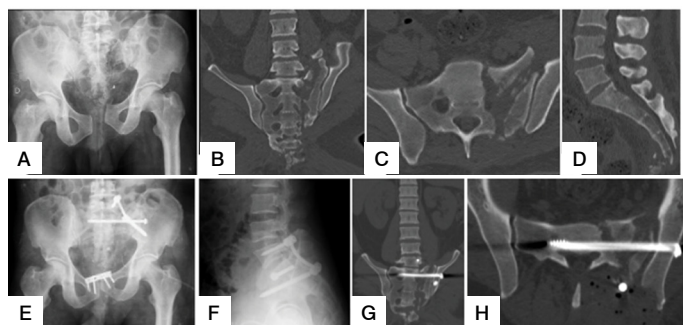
Male patient, 30 years old, a victim of a 9-meter fall with 30 days of evolution. On neurological examination, Gibbons 1. Imaging exams: a) Panoramic AP radiograph of the pelvis shows vertical ascension of the left hemipelvis; b) CT in the coronal reconstruction of the sacrum shows transforaminal fracture with displacement; cd) axial CT and sagittal sacral reconstruction; e) postoperative radiograph in the AP panoramic view of the pelvis: triangular assembly and osteosynthesis of the pubic symphysis were performed; f) postoperative radiography in lateral view; g) Postoperative CT: coronal reconstruction showing reduced vertical ascension of the left hemipelvis; h) Postoperative axial CT: positioning of the iliosacral screw.
